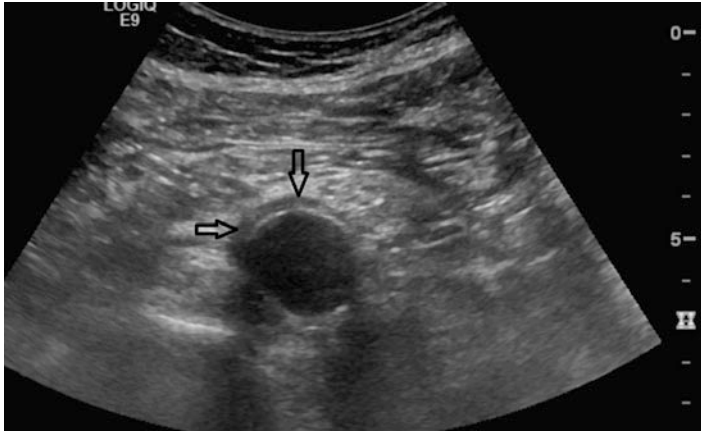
Duplex ultrasound of a 44-year-old man with isolated idiopathic aortitis showing vessel wall inflammation in the form of thickening (see *arrows*) in the abdominal aorta
